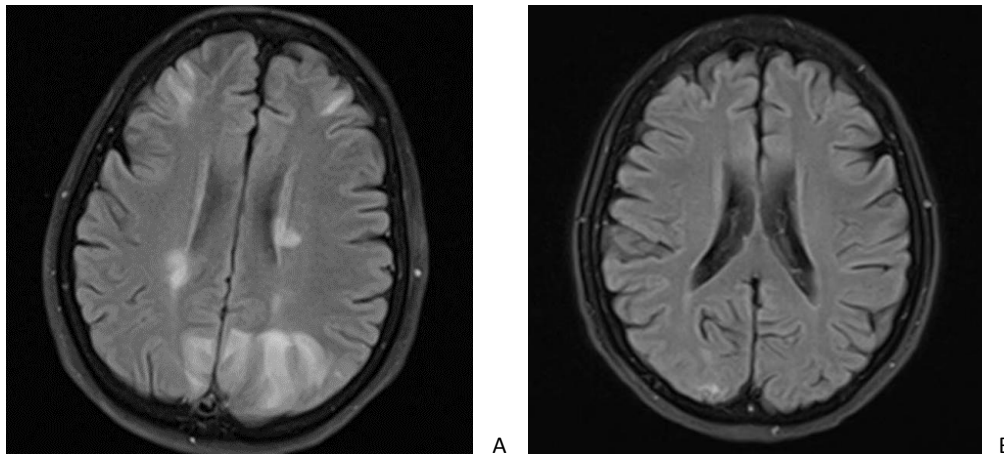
Brain magnetic resonance imaging (MRI), in FLIAR sequences showed hyperintensity in occipito-parieto-frontal with predominance in occipital lobes (A), with resolution of most hyperintensity in control brain MRI after 2 weeks (B).
